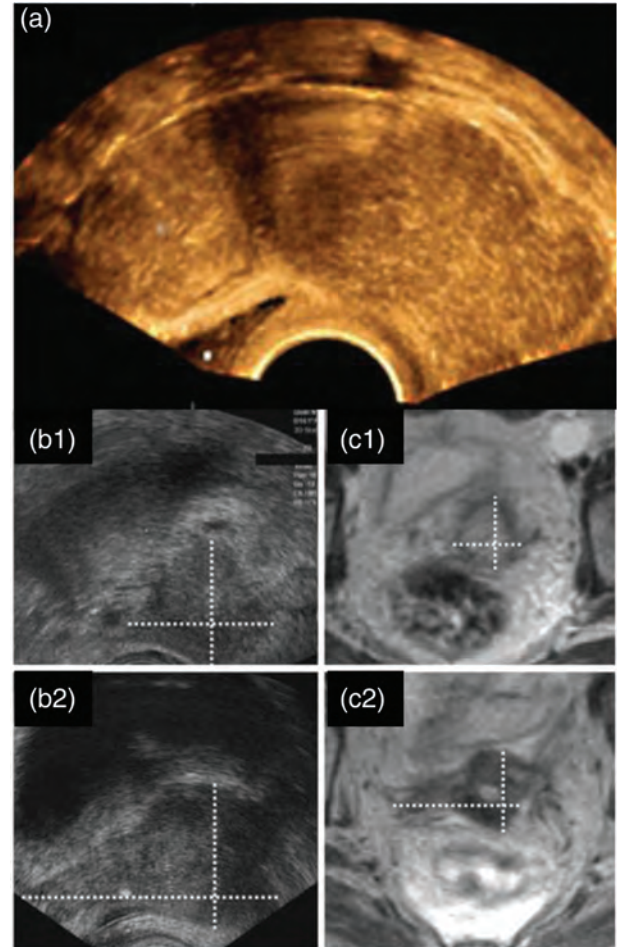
Ultrasound of cervical cancer: vaginal 3D endo-sonography of bulky cervical cancer infiltrating into the uterine corpus [from Figure 1.1. (Olpin and Tempny, 2011)]; trans-rectal US (b) and MRI (c) of advanced cervical cancer with bilateral proximal (1) and right distal (2) parametrial involvement at the time of brachytherapy without the applicator in place (Schmid *et al.*, 2013a).
